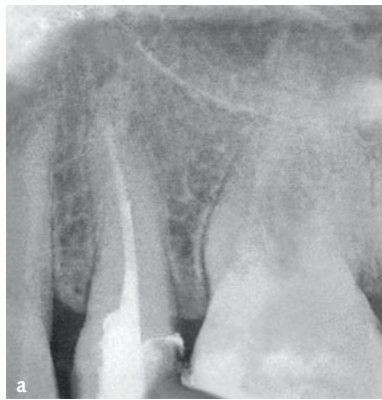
Poor quality radiograph which did not allow the correct diagnosis.
